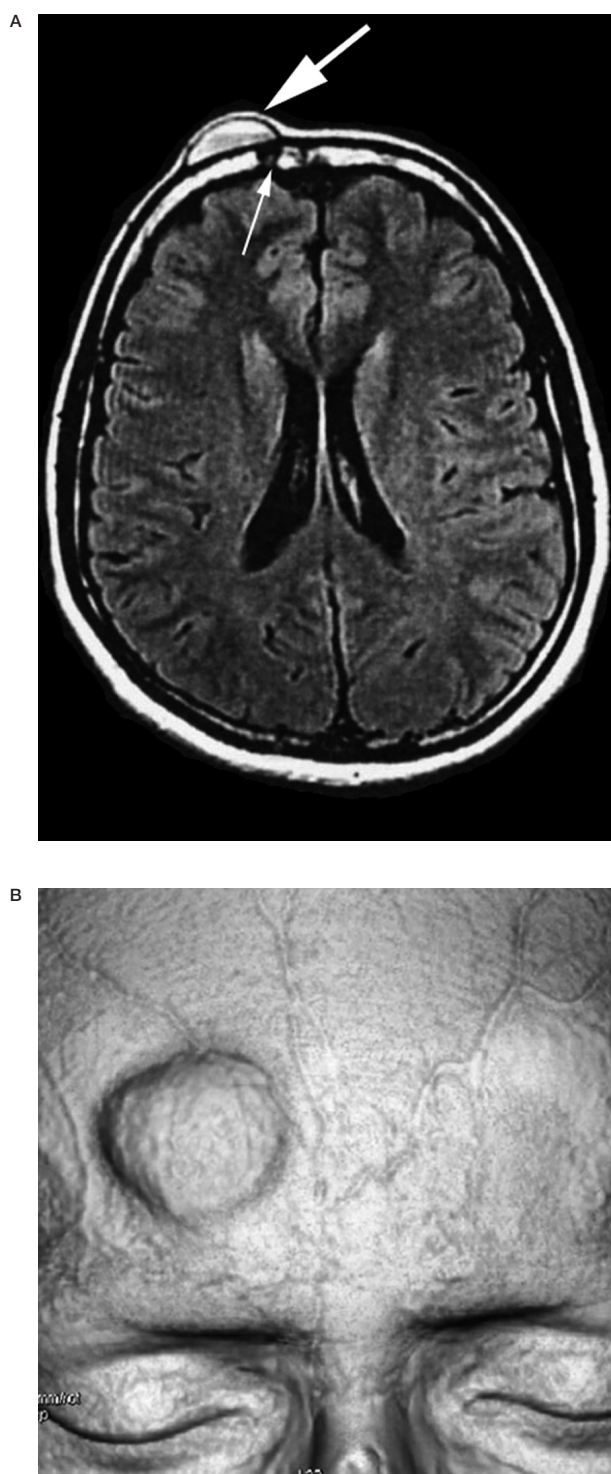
A) Flair T1 weighted MRI shows a mass in the scalp (thick arrow) overlying a small defect in the right frontal bone (thin arrow). Its hypersignal testifies that the lesion flow is very slow. B) Reconstructed 3D CT images shows the mass overlying the right frontal bone and demonstrate curvilinear grooves within the skull, corresponding to the course of the large draining veins.
